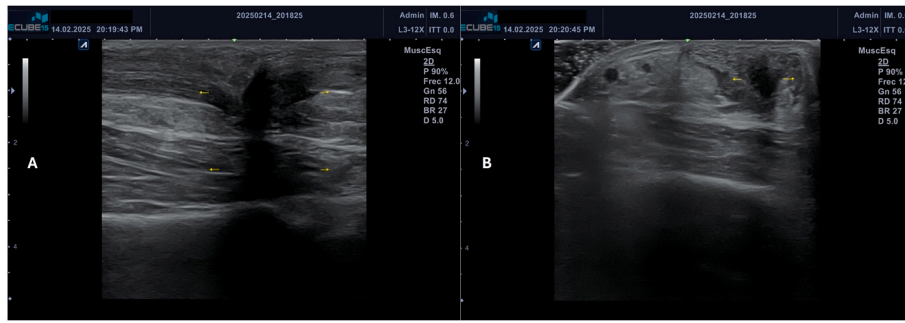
The longitudinal (A) and transversal (B) ultrasound images for diagnosis revealed a partial discontinuity of the Achilles tendon, measuring 5.5 mm in width, along with a similarly sized discontinuity of the soleus.
